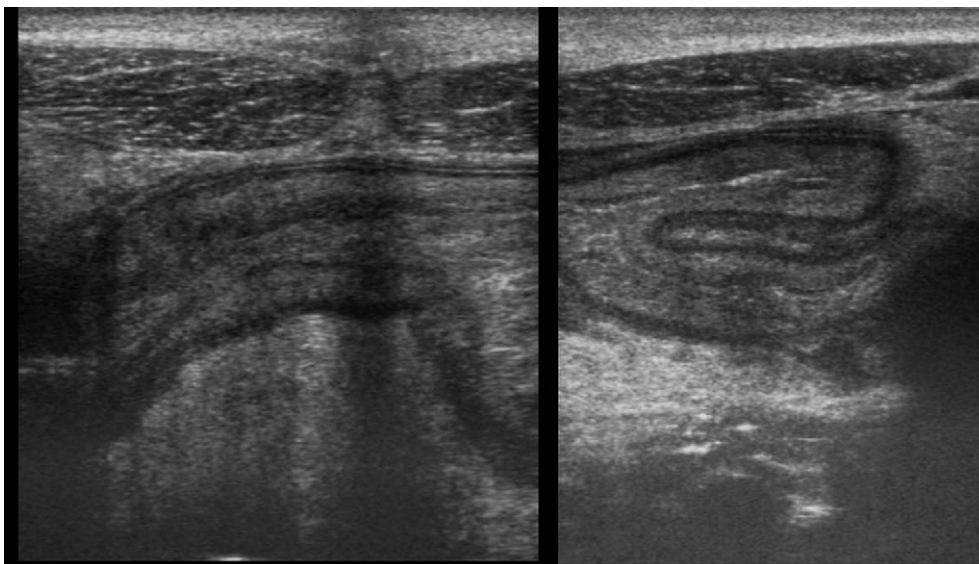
Transverse ultrasound of the abdominal wall in midline showing thickened loops of small bowel in a patient with active Crohn's disease.
